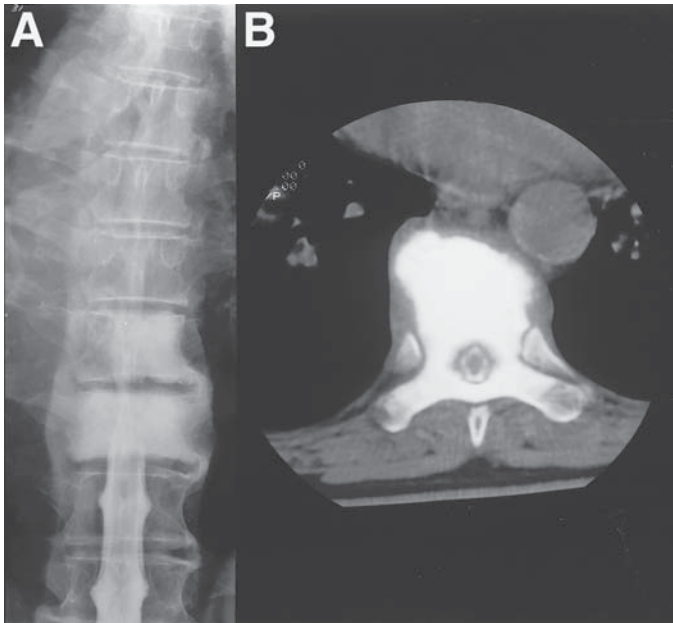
A 39-yr-old with HD presented with new back pain. A sclerotic thoracic vertebral body typical of the “ivory vertebra” of HD is shown on plain X-ray (A) and bone CT (B).
